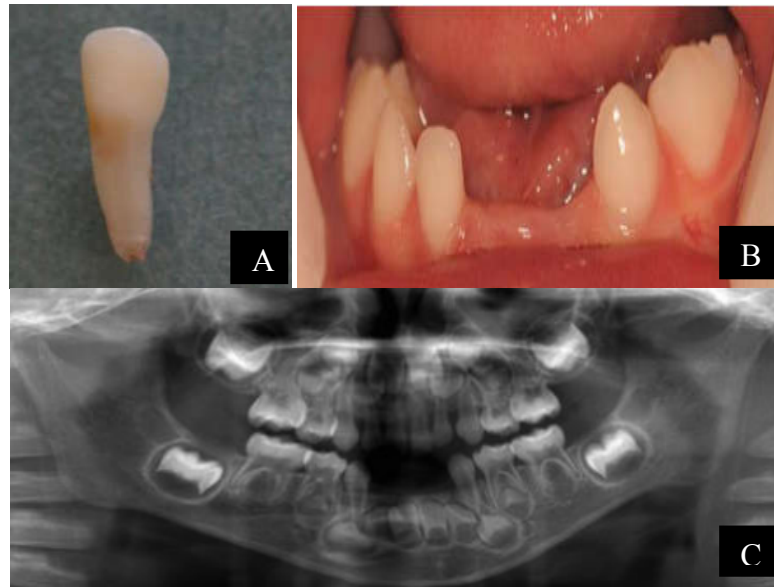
Photograph and X-ray of case 1: this is a boy aged 1 year and 7 months with PPH. (34) A: Photograph of the exfoliated tooth with an intact root. B: Photograph of the mandibular arch showing the absence of the 3 mandibular incisors. C: Panoramic X-ray showing a reduced level of the alveolar bone
